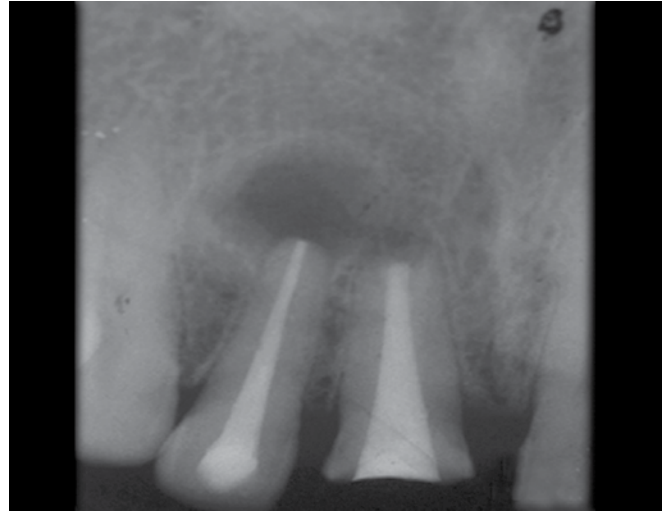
Immediate postsurgical radiograph
